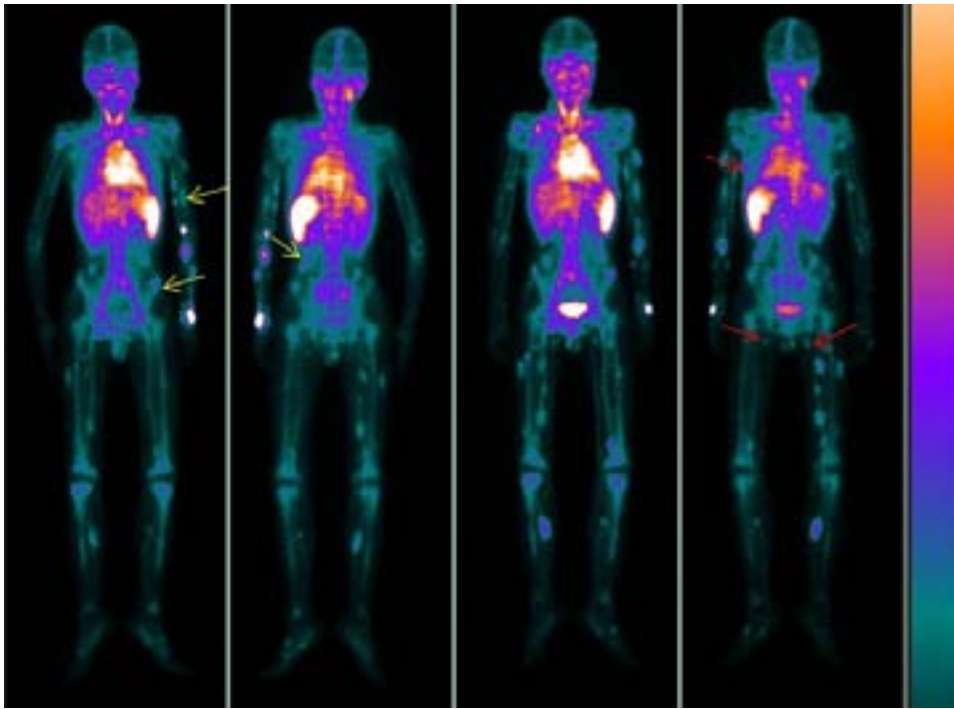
Whole-body blood pool scintigraphy of the patient. At 10 min, the images show extensive distribution of the radioactive tracer throughout the subcutaneous tissues of the extremities, trunk and small intestine (yellow arrows). At 3 h, radionuclide pooling abnormally increased as compared with that at 10 min (red arrows).
